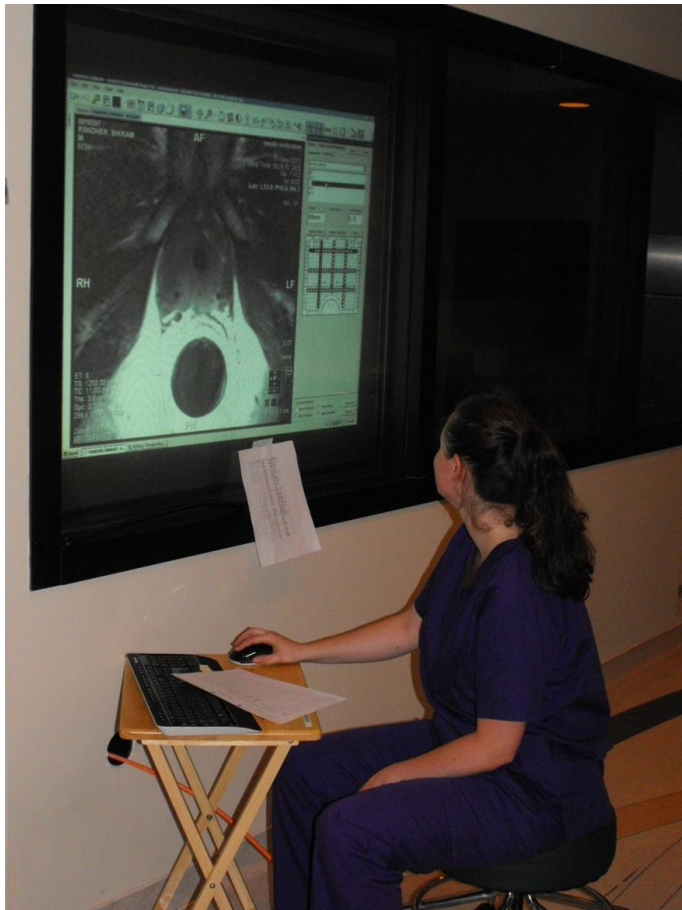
Catheter navigation using navigation software with in-room control of MRI using remote commands.
